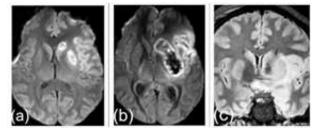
(a) Early post-operative MRI brain shows minimal infarction seen in left ganglio capsular region.
